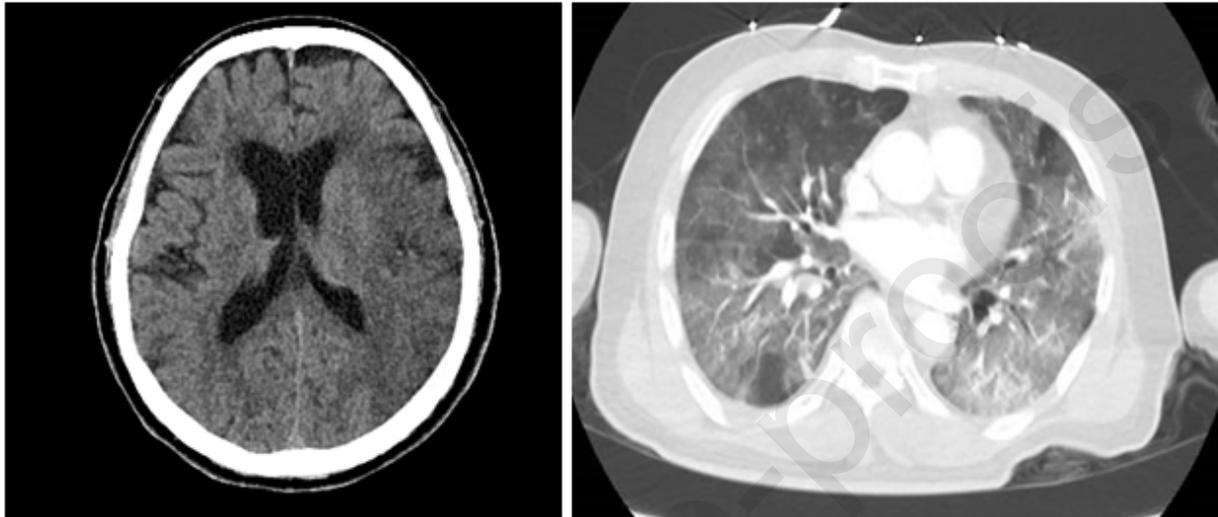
A CT of the head demonstrated loss of gray-white differentiation at the left occipital and parietal lobes, consistent with acute infarct
